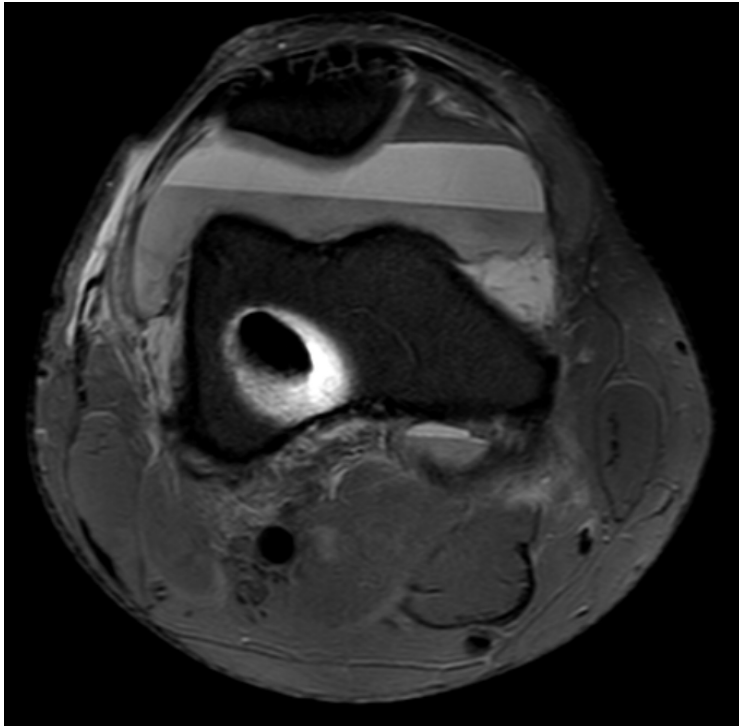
Axial PDW MRI showing lipohemarthrosis in a 30-year-old patient following trauma after post ACL reconstruction.
